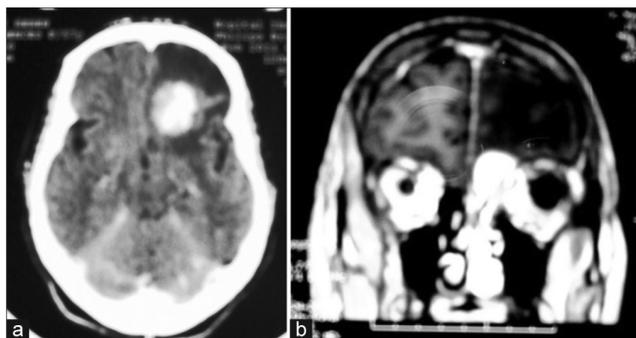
(a) Tomodensitometry shows intracranial and extracranial expansive processes, localized in the left frontal lobe; (b) MRI shows a lesion localized in the anterior floor on the base of the skull, reposing on the sphenoid bone and the orbit roof, and crosses the perpendicular plate.
